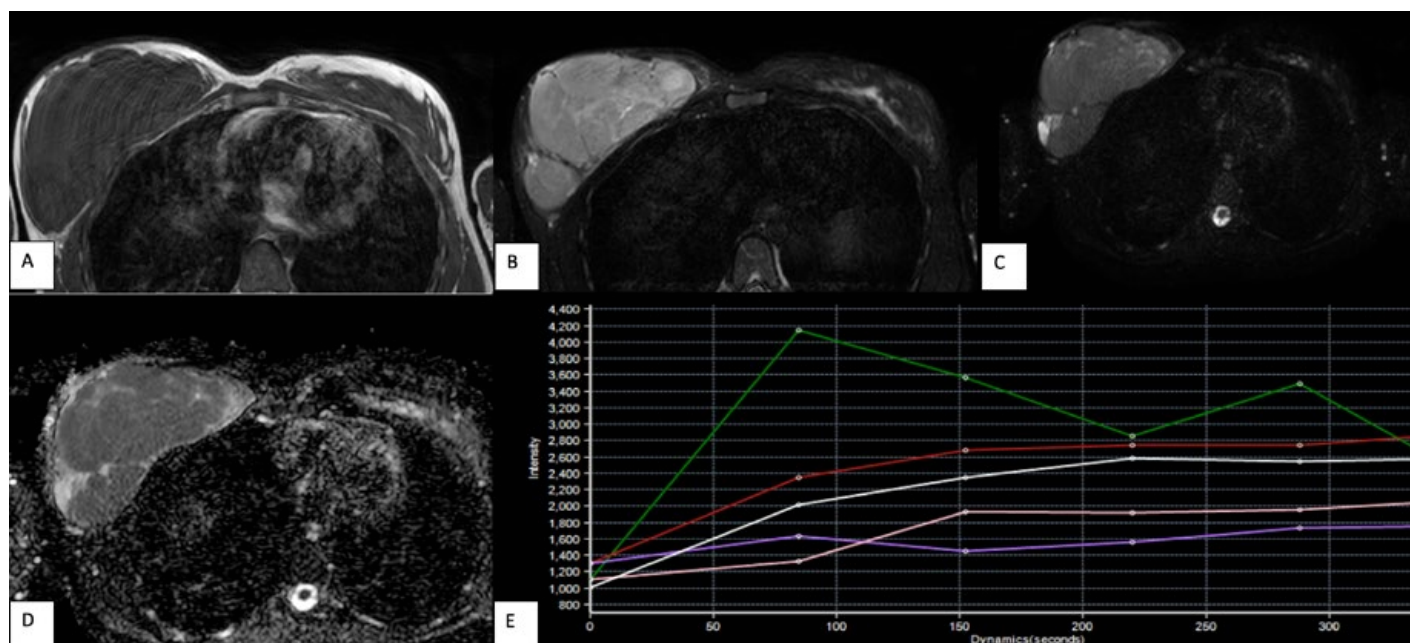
A and B) Axial T1-weighted and axial STIR images reveal a well-defined, lobulated mass lesion replacing the right breast parenchyma, appearing hypointense on T1-weighted images and heterogeneously hyperintense on STIR images, showing internal septations. C and D) DWI and ADC images reveal no restriction of diffusion. E) Postcontrast images show homogeneous enhancement with a rising type of enhancement curve (Type I; red and white curves; green curve represents normal vascular enhancement).
